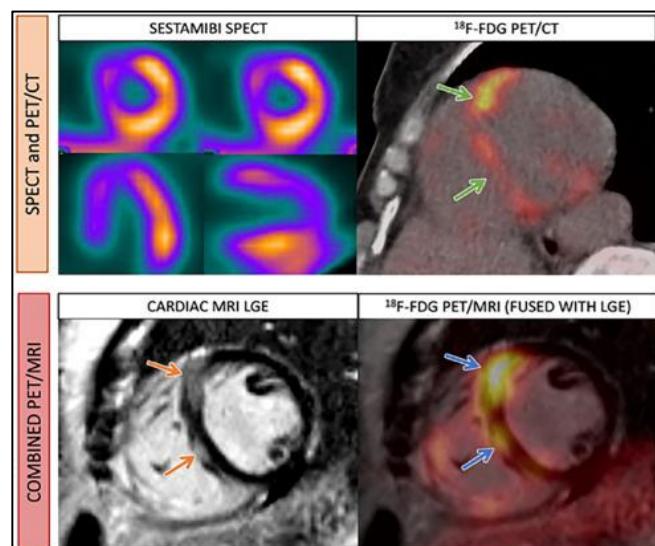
FDG PET/MR Fusion in Cardiac Inflammation or Viability Imaging: MRI Anatomical Overlay with Metabolic FDG Uptake Map Showing Focal Uptake in Myocardium
